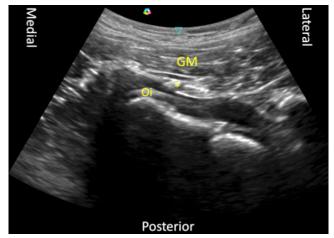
Move the ultrasound probe caudally in the parasacral view. GM: Gluteus maximus muscle; Oi: Obturator internus muscle; * PFCN and sciatic nerve.
